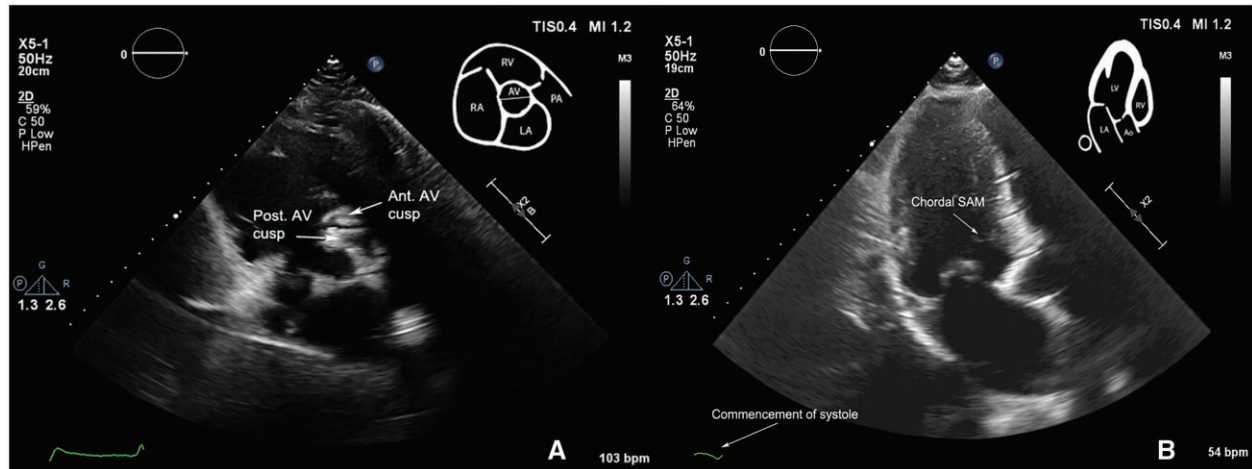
Preoperative transthoracic echocardiogram. (A) Parasternal short-axis view showing thickened, sclerotic, true bicuspid aortic valve. (B) Evidence of chordal SAM on apical three-chamber view, with increased gain.
